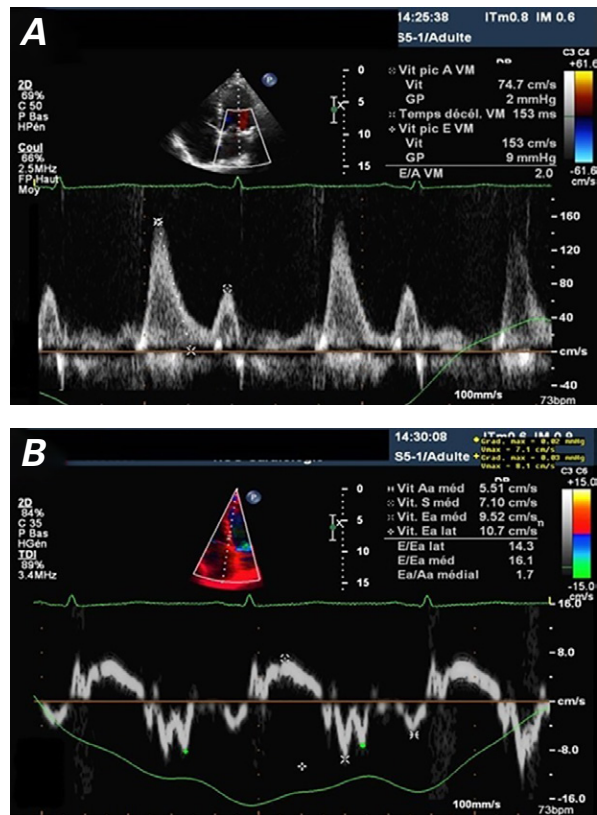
Mitral Doppler echocardiograms show signs of constrictive pericarditis: A) restrictive filling ($E/A > 1.5$; short deceleration time) and B) normal annular velocity ($e' > 7$ cm/s, but in this case lateral $>$ septal).
